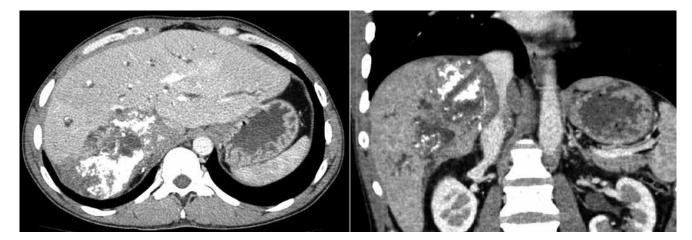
Computed tomography of the abdominal organs of patient I., axial and coronal reconstruction, venous phase. In the right lobe of the liver, there is a massive heterogeneous zone with calcification
